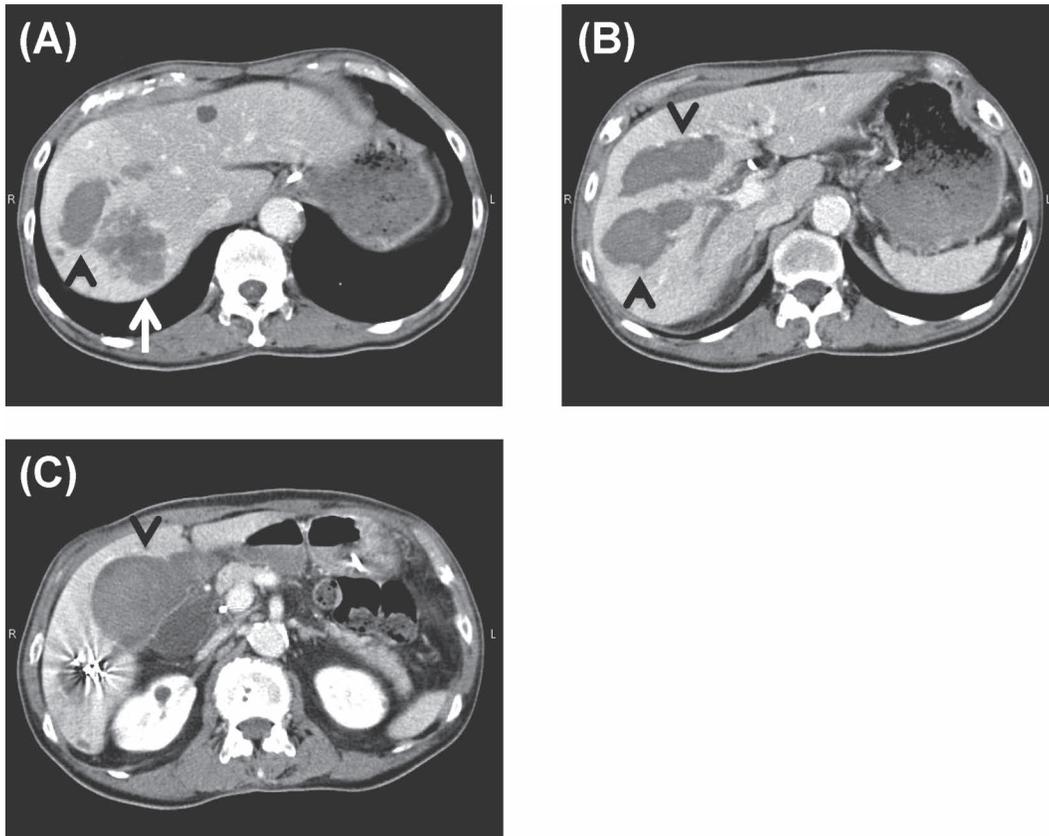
Enhanced computed tomography revealed a 50-mm-diameter metastatic liver tumor in segment 7 (A ; arrow) and multiple intrahepatic hematomas in the right hepatic lobe (A-C ; arrow heads).
